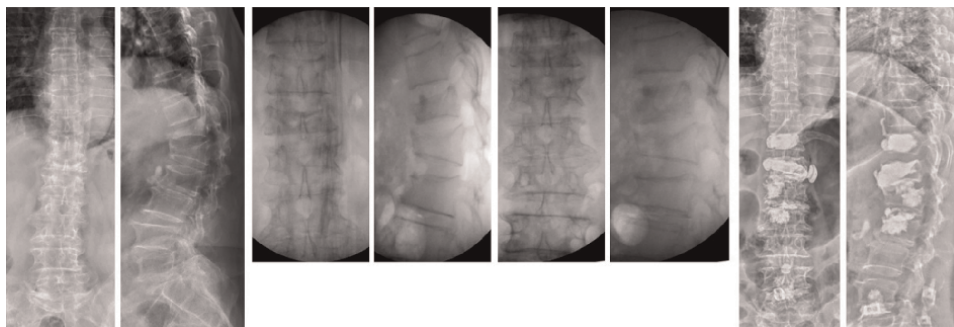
Demonstrated radiographs of a 71-year-old female with T11-L2 kyphosis, T11-L2 lateral Cobb's angle pre-op: 50°; postural reduction: 34°; post-manual reduction: 19°; post-vertebroplasty 12°. Cement vertebroplasties (T11,12,L1) and discectomy (T12/L1) were done due to simultaneous reduction of vertebral body and disc.
